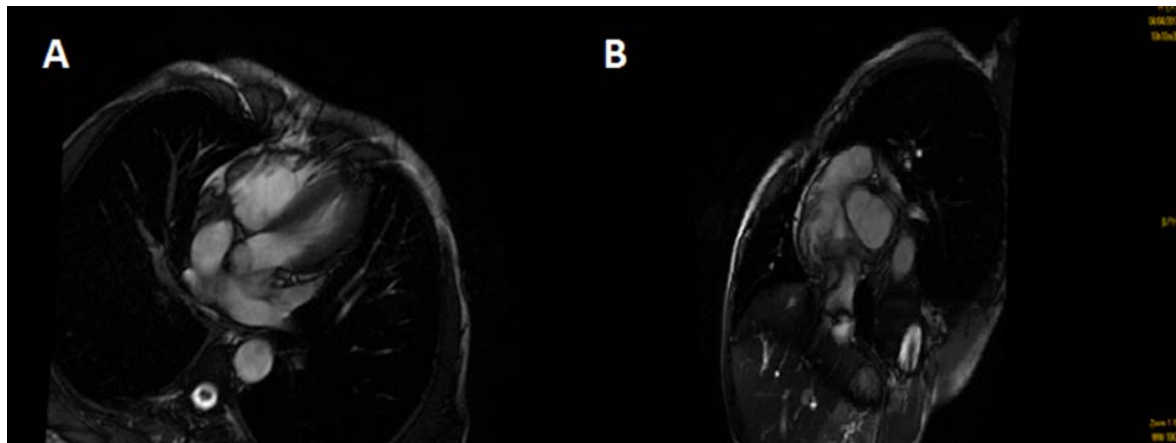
A, B: MRI objectifying Cor Triatrium
